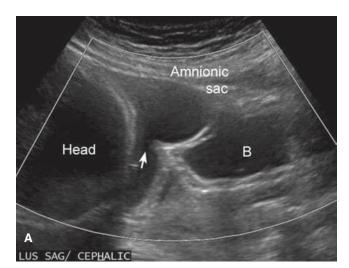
Extensive "uterine window" in a woman at term with one prior low transverse cesarean delivery. A. Transabdominal sonogram shows the uterine defect (*arrow*), bulging amnionic sac, and adjacent anatomy. B = Bladder. B. At the time of cesarean delivery, the amnionic sac is seen protruding through the defect and is visible beneath the thin vesicocervical peritoneum. (Reproduced with permission from Dr. Angela Seasley.)
